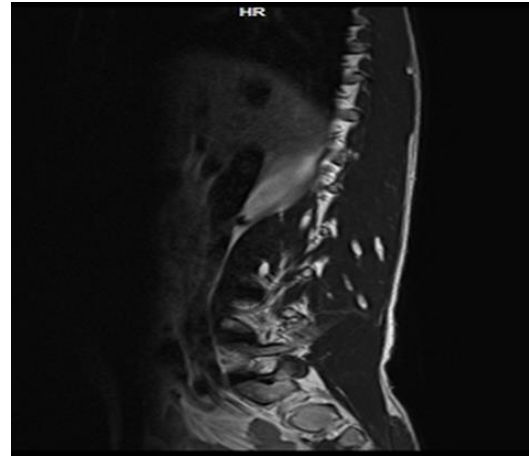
MRI Spinal Cord: Saggital T2W: showing hyperintense signals in paraspinal muscles suggestive of cysticerci.
